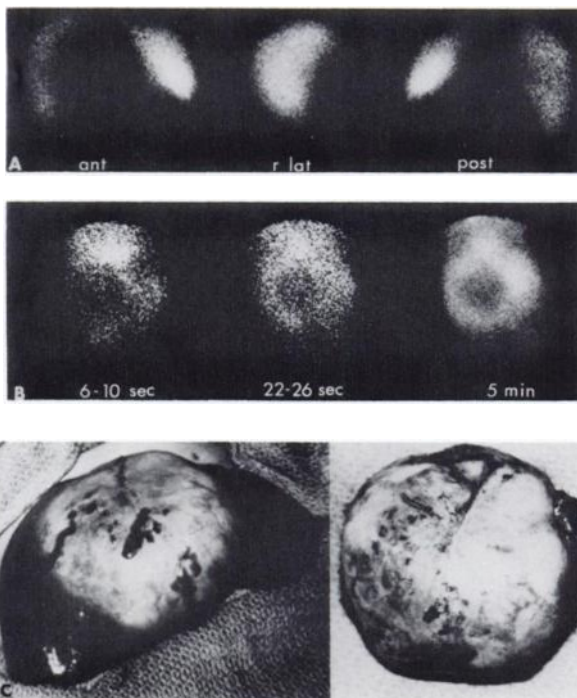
(A) ^{99m}Tc-sulfur colloid liver scan, anterior, right lateral, and posterior views. Note decreased radioactivity in region of right and left liver lobes. (B) Rapid sequence hepatic scintigraphy reveals total avascularity in that region. (C) Shows actual mass in the liver. On resection, encapsulated hematoma around a small hemangioma (arrow) was seen.
